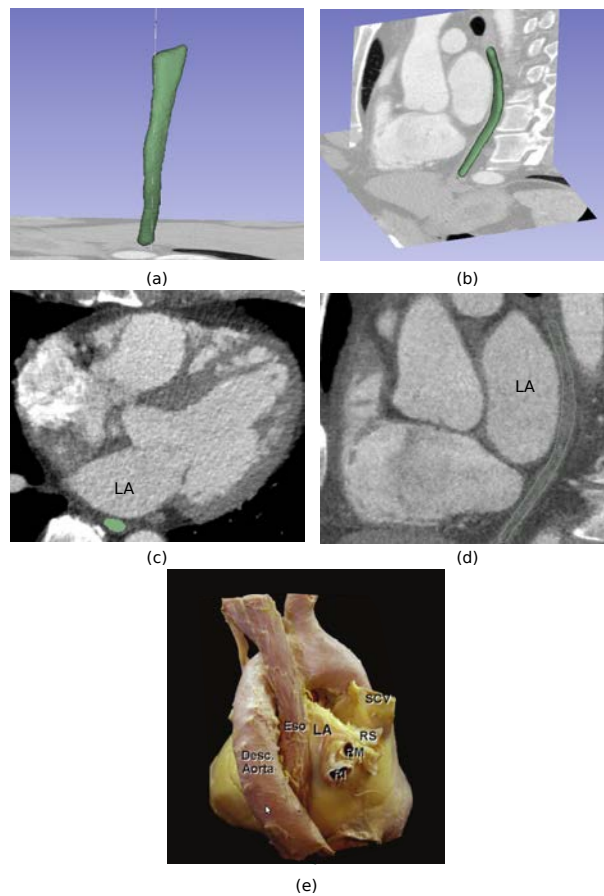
Results for semi-automatic esophagus segmentation on CT dataset. Posterior (a) and anterolateral (b) views of the resulted esophagus mesh. Axial (c) and sagittal (d) slices from the CT volume. The result of the segmentation is delineated in green. (e) Human heart viewed from the posterior perspective, to show the esophagus (HO et al. 2012). LA: Left atrium; Eso: Esophagus; SCV: Superior Caval Vein; RI: Right Inferior; RS: Right Superior Pulmonary Veins.
